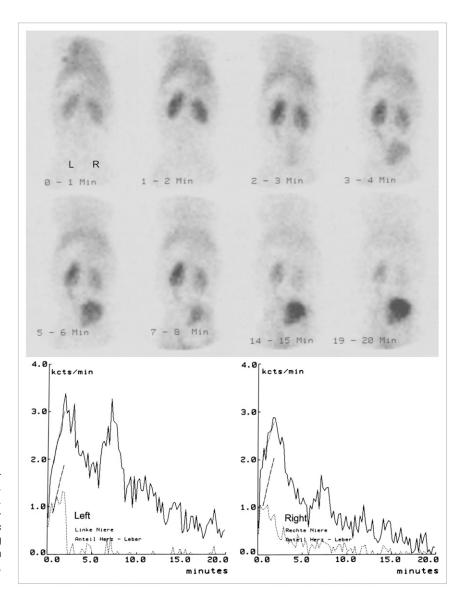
Preoperative study identified normal renograms for both kidneys. Note spike due to movement artifact. Single-kidney contribution to total function was 52% (left) and 48% (right). Pelvic activity was clearly recognizable during third minute. At 20th min, tracer excretion was nearly complete. After scintigraphy, ligature was placed around right ureter.
